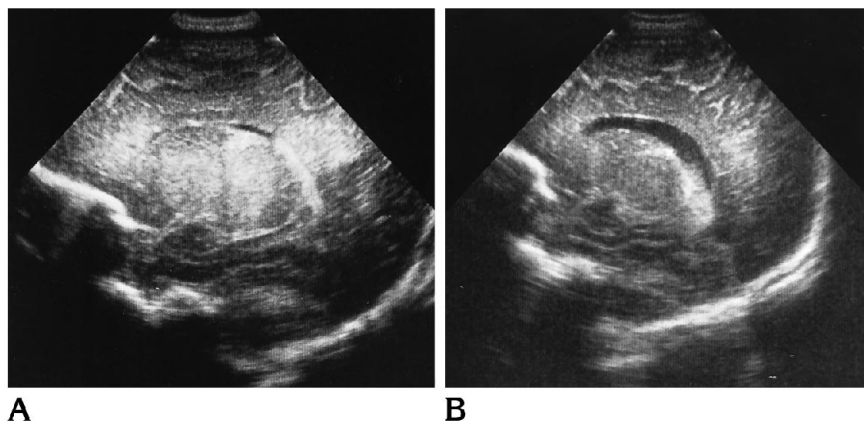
Ultrasonography examination. Comparison of two sagittal scans before (A) and 4 weeks after (B) institution of therapy shows hyperechogenicity of periventricular white matter, thalamus, and pallidus (A) and regression of ultrasonography abnormalities (B).
